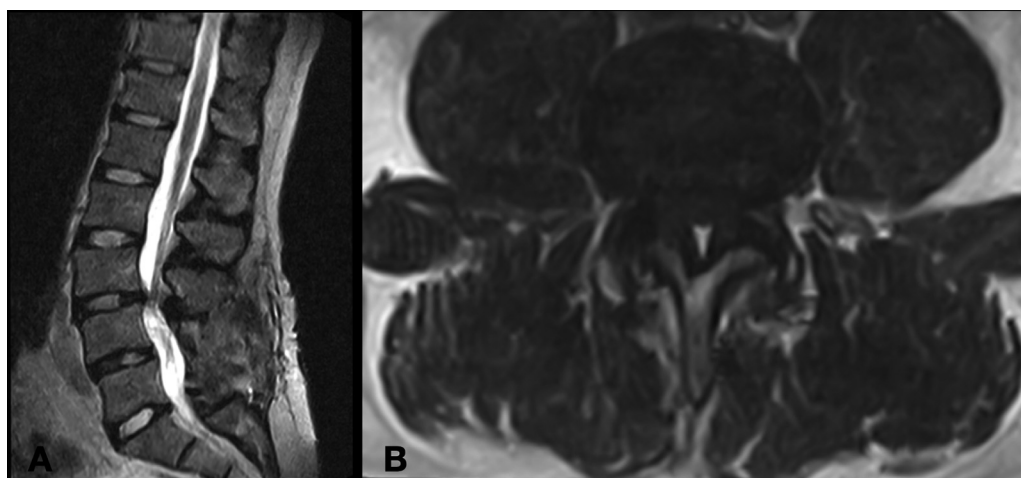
(A) Sagittal and (B) axial views of the preoperative T2-weighted magnetic resonance imaging showing spinal stenosis due to adjacent level segment disease at L3-L4 in a 47-year-old male who previously underwent L4-L5 posterior lumbar fixation.
